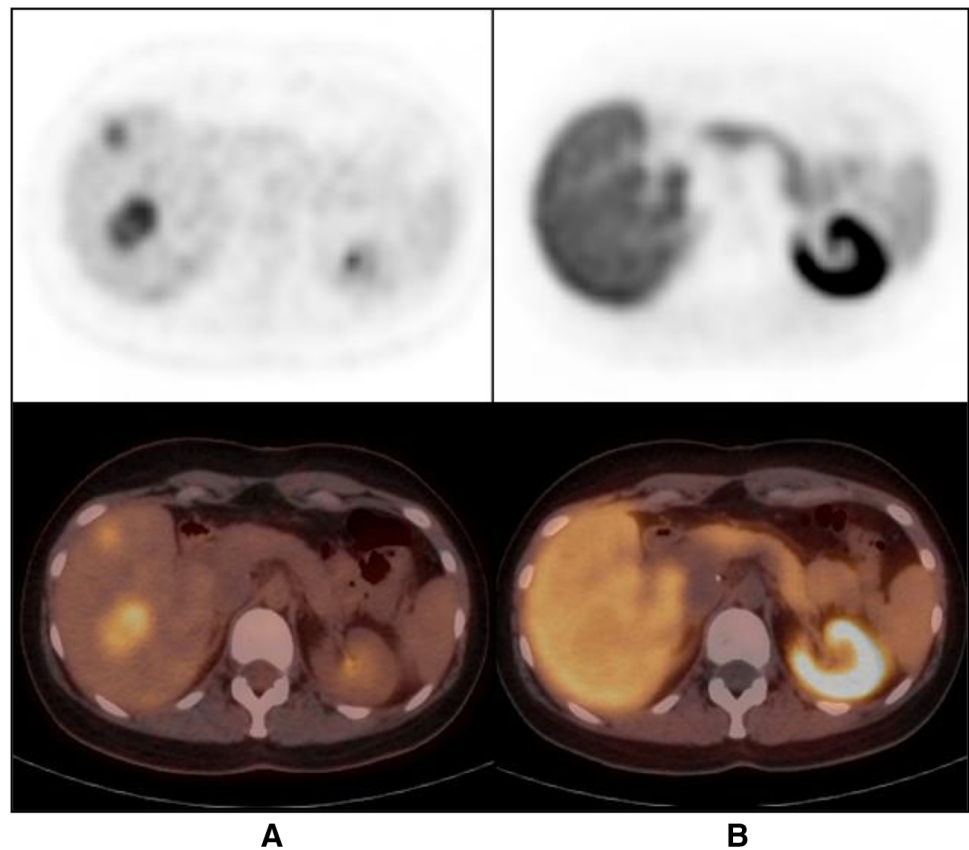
Liver adenoma has no typical pattern on FDG or FCH PET/CT. It can be FDG-positive (a) and non-visible on FCH PET/CT (b), as in this patient with multiple adenomas, but it is frequently negative with both tracers (color figure online)
